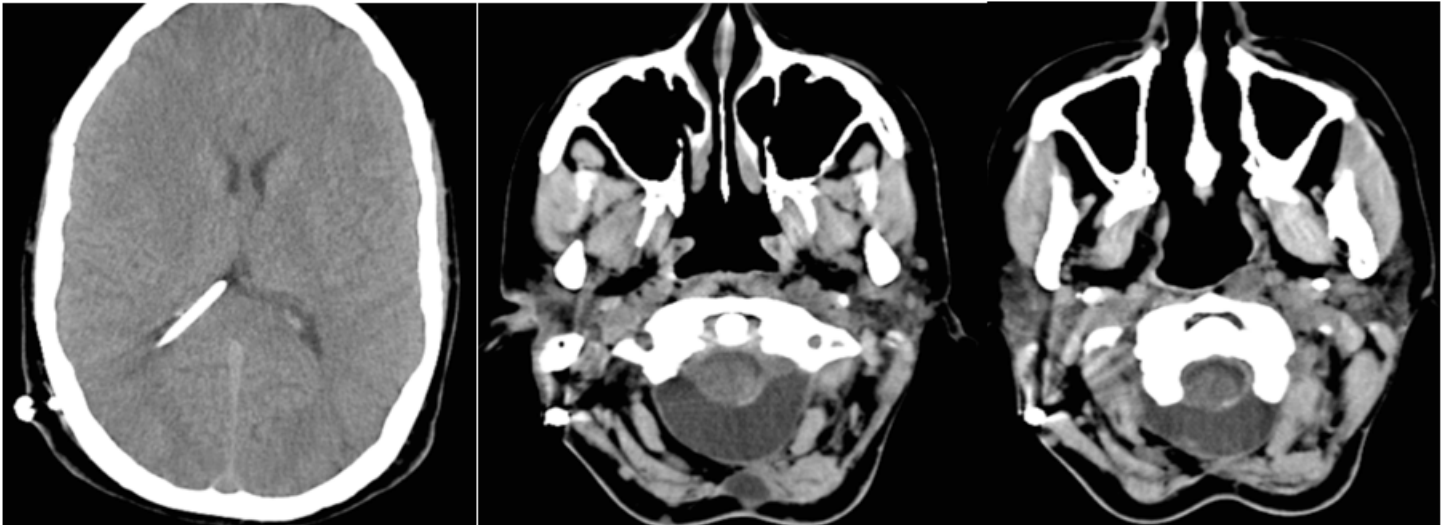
Serial CT scan after ventriculoperitoneal shunting, meningocele diminished on serial CT scan.
